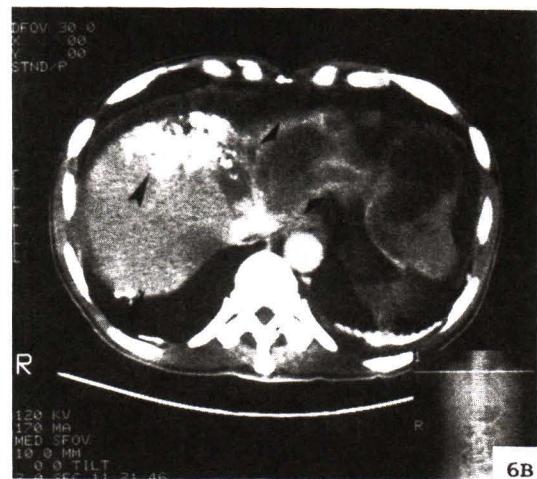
Lipiodol CT scan of the same liver shown in Fig. 6 A taken 4 weeks after TOCE shows heterogenous retention of lipiodol in the right lobe of the liver (big arrow head) and no accumulation of lipiodol in left lobe liver due to AV shunting as seen in Fig. 6A (small arrow head).
